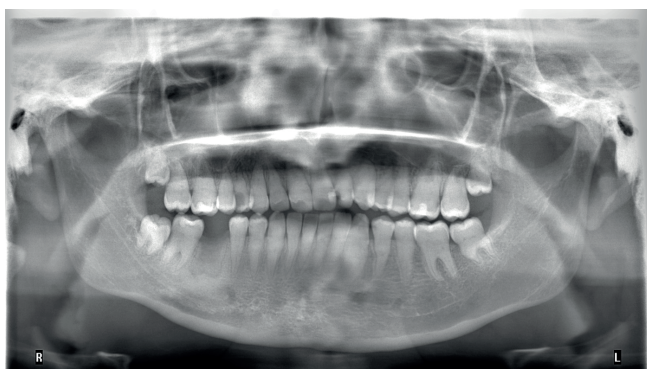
Patient's panoramic image; The X-ray was taken when the patient first applied to the faculty
